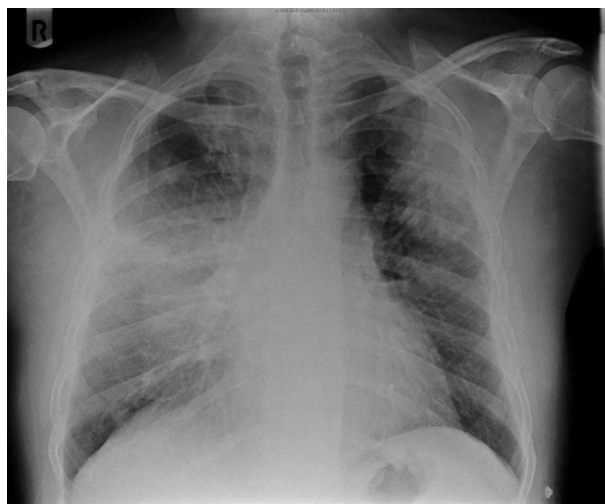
Chest radiograph showing multifocal bilateral consolidation. There is a diffuse, poorly margined, increased opacity in the right midzone and enlargement and increased density of the soft tissues, suggestive of a chest wall mass.
